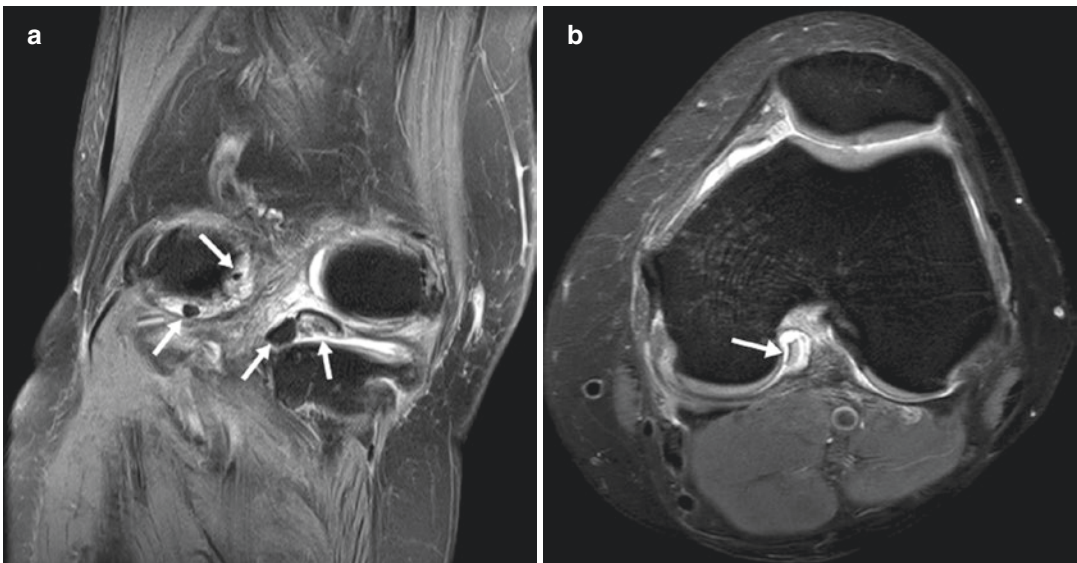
(a) Fat-suppressed proton density-weighted coronal MRI image shows several small ovoid and globular loose bodies (arrows) in the knee. (b) Fat-suppressed
